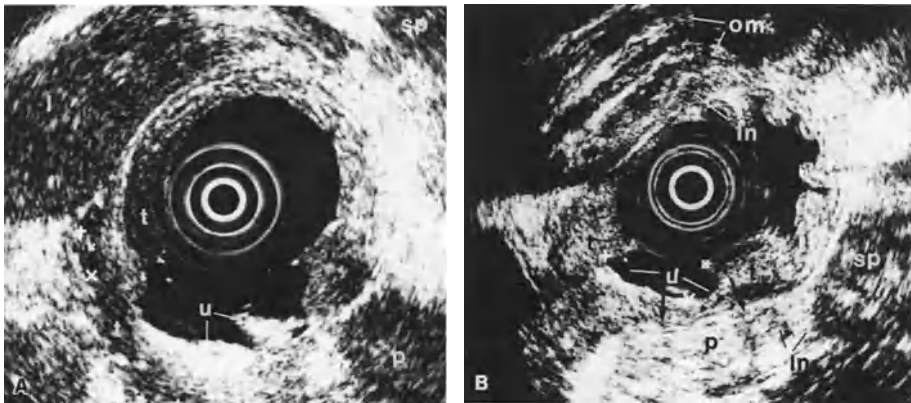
A, B. Endoscopic sonograms. A Hypoechoic tumor (*t*) penetrating deeply into the pancreas (*p*) adjacent to an ulcerative lesion (*u*). *l*, liver; *sp*, spleen. B Tumor (*t*) adjacent to an ulcer (*u*) with some slight penetration (*arrows*) into the pancreas (*p*), associated with multiple lymph nodes (*ln*). *om*, omentum majus
